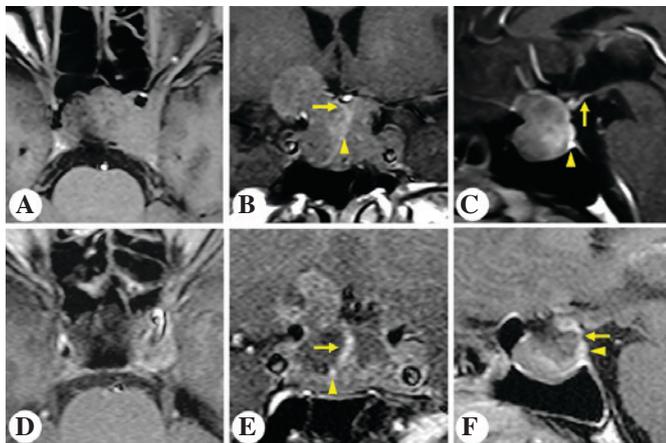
Patient 3*. Representative post contrast T1-weighted images. Preoperative (A) horizontal, (B) coronal and (C) sagittal and postoperative (D) horizontal, (E) coronal and (F) sagittal magnetic resonance imaging of the sellar region. Arrows indicate the pituitary stalk. Arrowheads indicate the pituitary gland.
